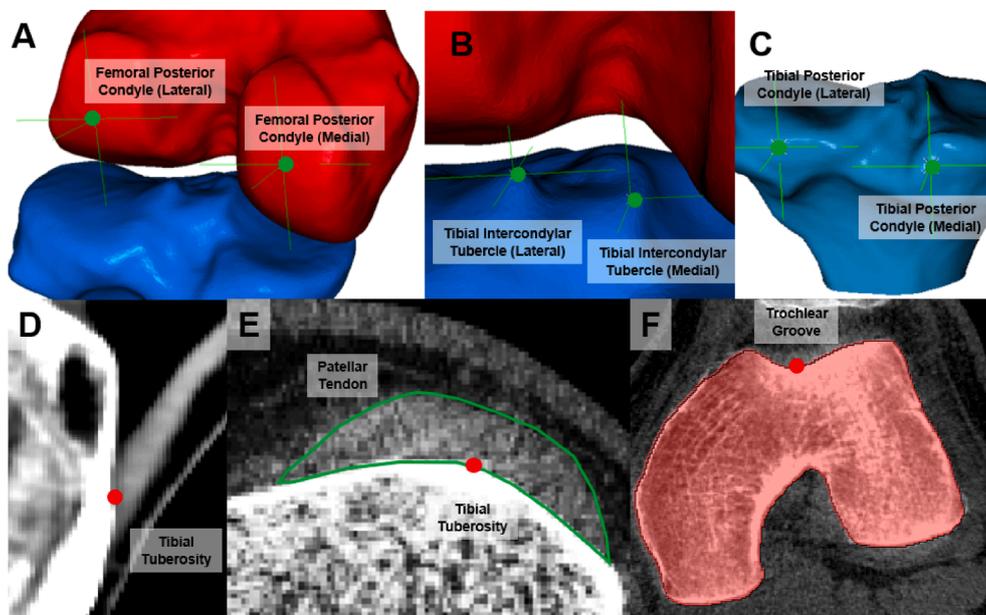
The landmarks for TT-TG calculation were placed using segmented 3D models and the axial and sagittal slices of the CT scans. (A, B, & C) shows landmarks placed on the 3D models, (D & E) show that the tibial tuberosity was specified as the middle of the patellar tendon attachment site, (F) shows the landmark in the trochlear groove placed at its deepest part at the height of the transition point as specified by Yu<sup>27</sup>. In total, nine landmarks were placed in the segmentation software. 3D = three-dimensional; CT = computed tomography; TT-TG = tibial tuberosity to trochlear groove.
